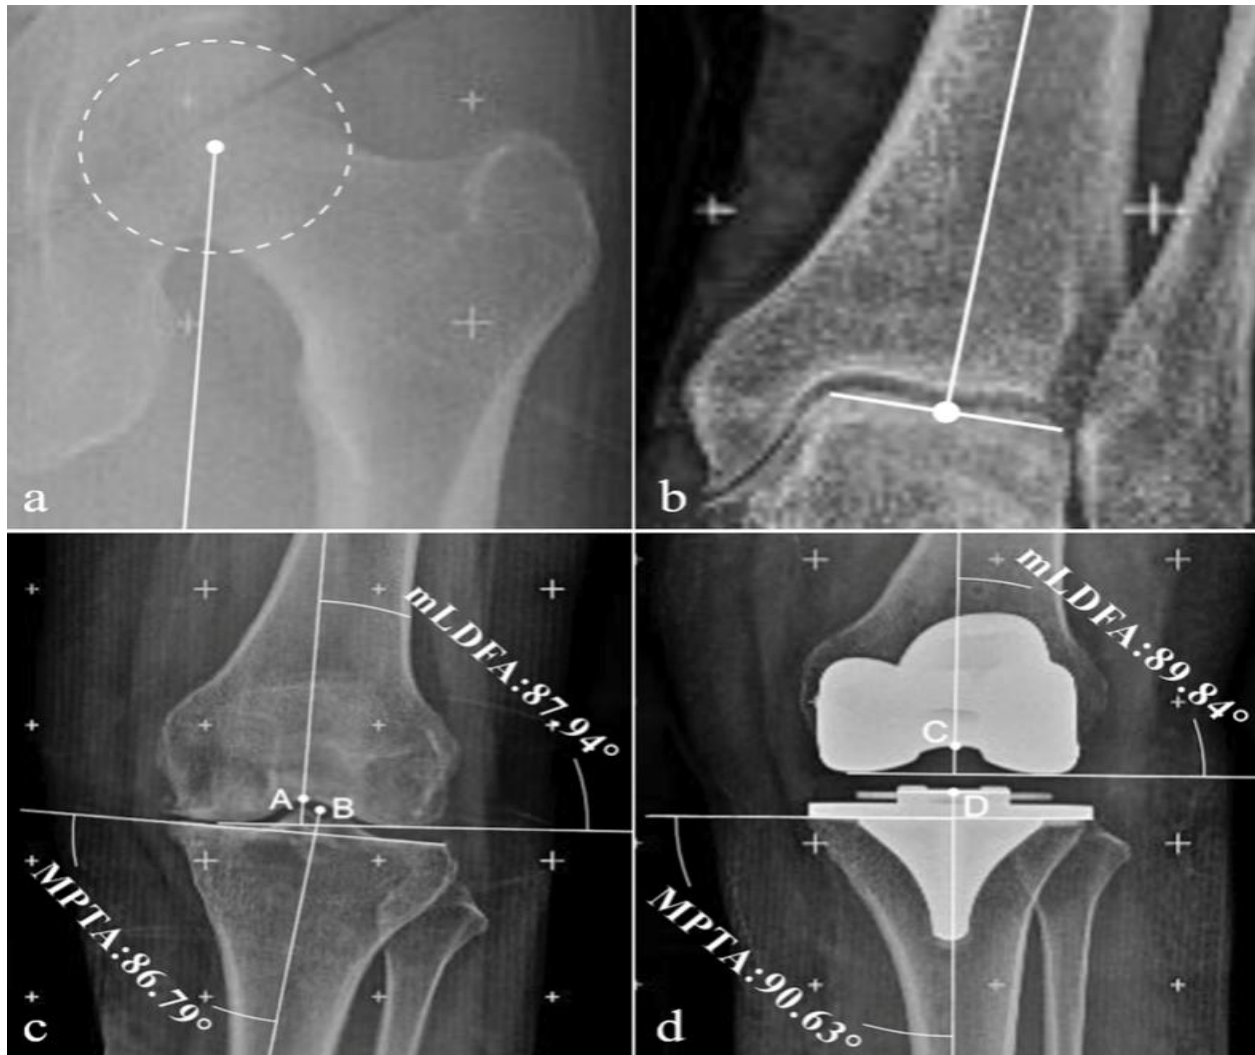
Use of CT imaging to support pre-operative planning using a Chinese-based robotic system known as HURWA; a) determination of the centre of the femoral head via a MOSE circle, b) centre of the ankle joint at the talus, c) pre-operative mechanical axis hip-knee-ankle angle and the medial proximal tibial angle and d) post-operative angles as for c) with C representing the apex of the intercondylar implant and D reflecting the centre of the tibial plateau implant [98].
